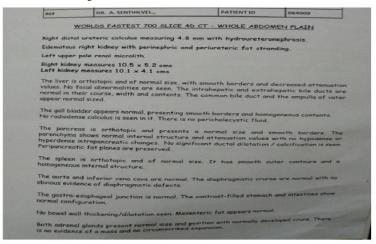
case 2- CT whole abdomen before treatment.
